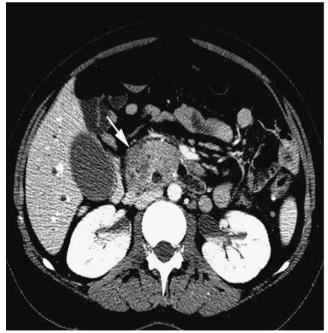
Axial contrast-enhanced computed tomographic image reveals a 3.5×2.5 -cm hypoechoic mass (*arrow*) located between the head of the pancreas and the second portion of the duodenum.
